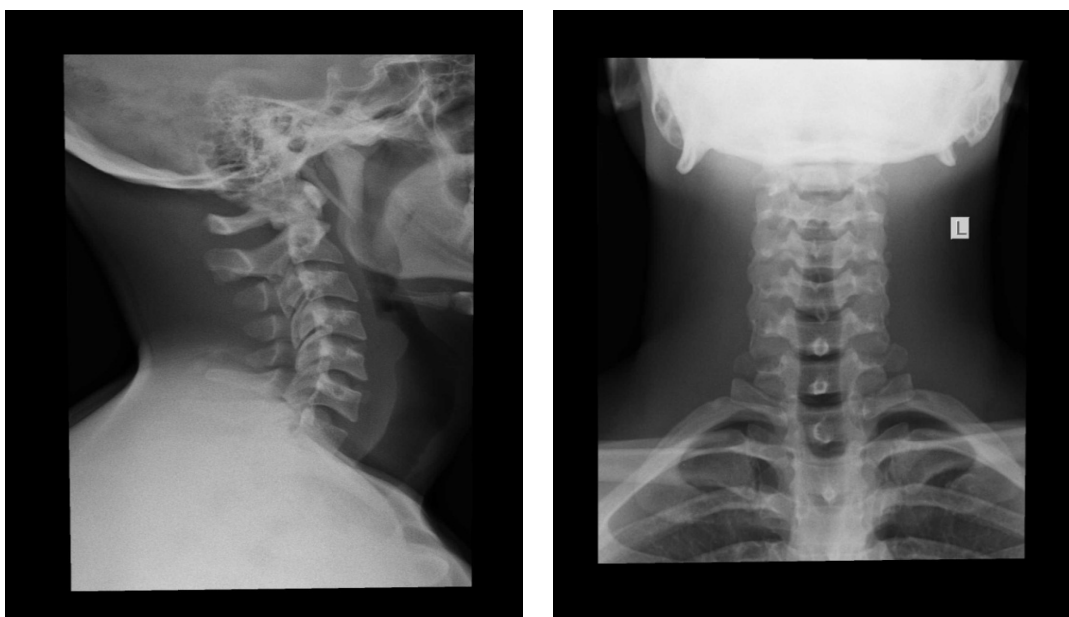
cervical spine xray of the patient showing normal findings
